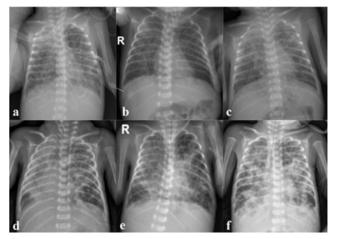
Chest X-ray findings of the child (a:15 days of birth; b:19 days of birth; c:24 days of birth; d:28 days of birth; e:29 days of birth; f:33 days of birth). Diffuse granular shadows were seen in Chest X-ray.
